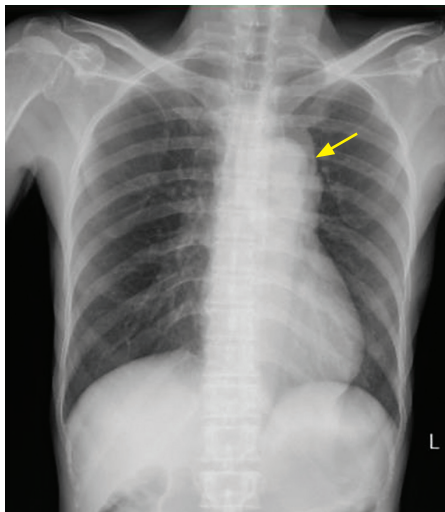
Chest x-ray showing mediastinal anterior mass (yellow arrow).
